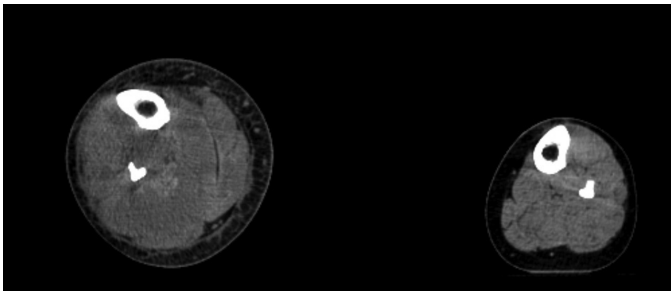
Image of a 16-year-old woman who was rescued under the wreckage. Axial unenhanced CT showing swelling of the muscles of the right lower leg. CT, computed tomography.
